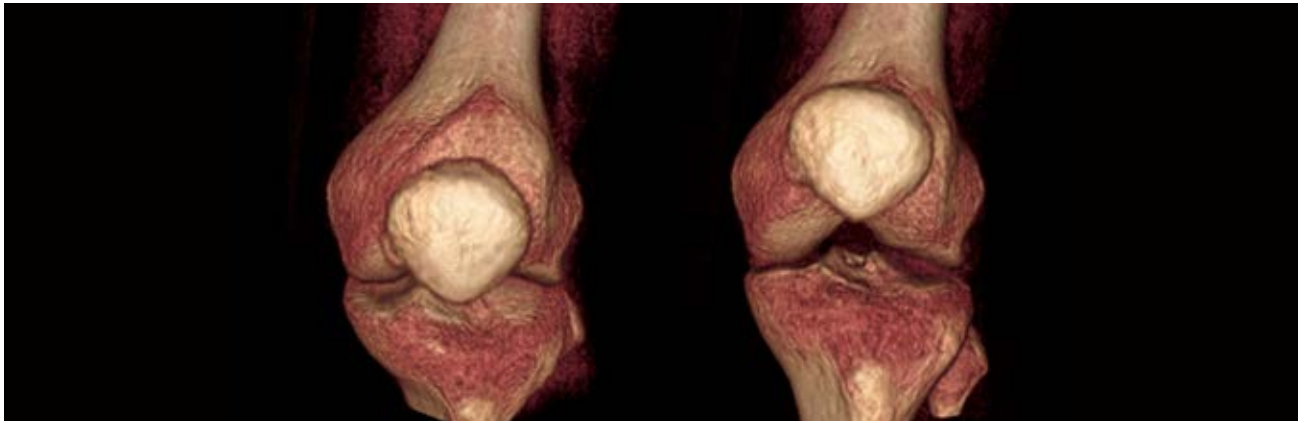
Preoperative imaging using CT for a patient with right knee prone to dislocation of the kneecap. Note how the kneecap moves to the side as the patient reaches full extension of the knee.
